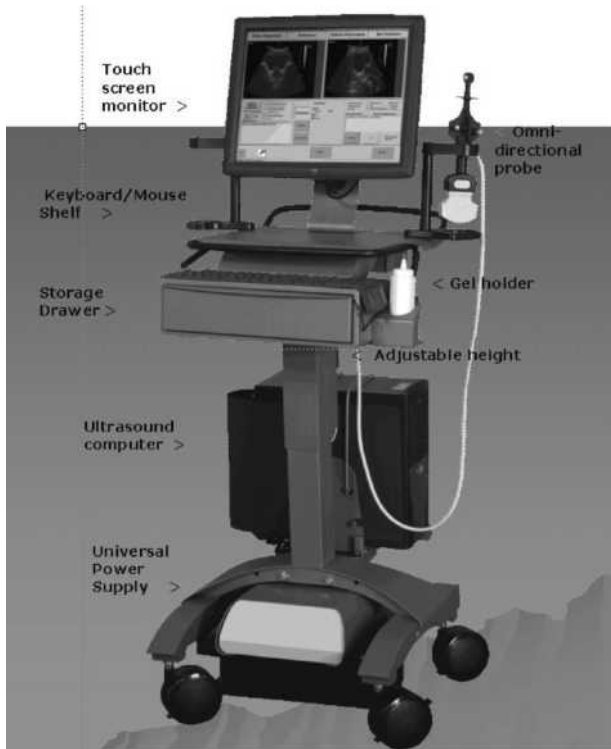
An ultrasound imaging device used to verify reproducibility of patient position for radiation treatment of the prostate. (Figure courtesy of NOMOS Radiation Oncology division of North American Scientific.)
